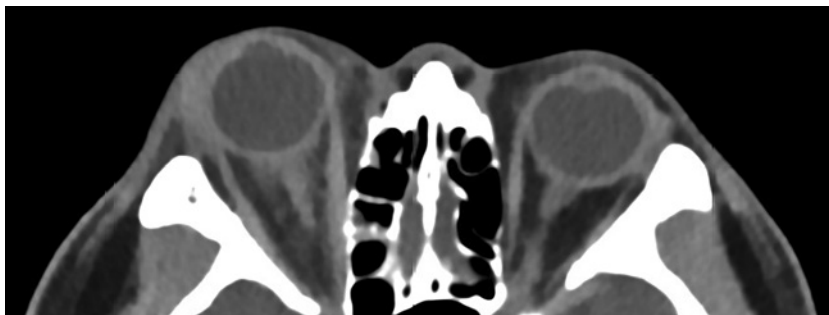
Axial CT scan with intravenous contrast, showing diffuse inflammation in the right orbit.
